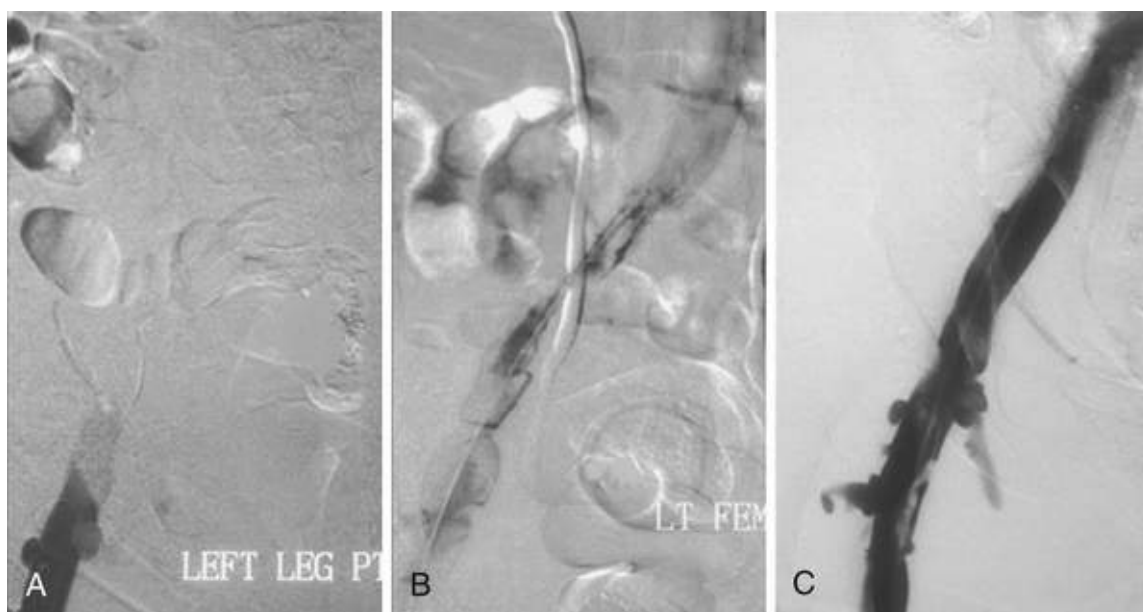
Venogram and intervention. A venogram of the left femoral vein was obtained after gaining access to the popliteal vein under ultrasound guidance. The patient is lying face down on the table to allow access to the popliteal vein. A, Baseline showing occlusion of the left femoral vein. B, Multihole catheter across the venous occlusion; administration of lytic agents is started. C, Four hours after lysis following percutaneous transluminal angioplasty and placement of a self-expanding stent to restore patency.
